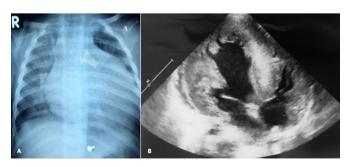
Radiological findings of infant B at the age of 7 months. (A) Massive cardiomegaly on chest X-ray, (B)short axis view of the heart demonstrating severe biventricular hypertrophy on echocardiogram.
